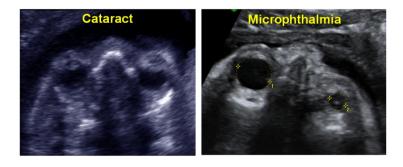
Ultrasound findings in fetuses with congenital rubella $338x190mm \ (96 \ x \ 96 \ DPI)$
